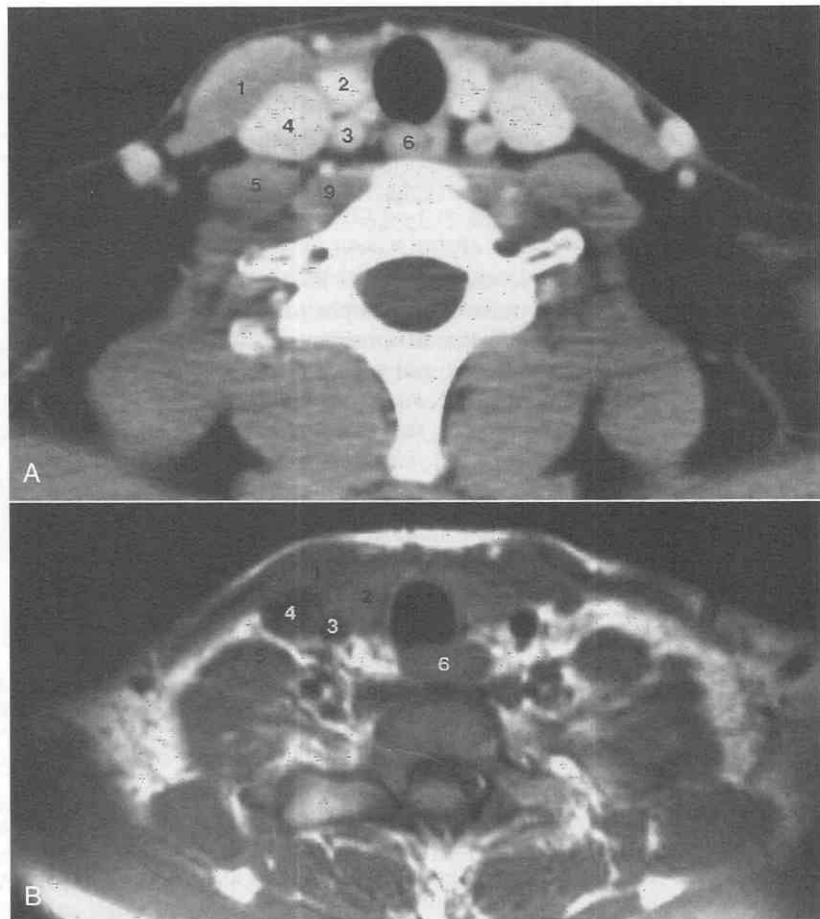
Nodal chains of the neck. (From Reede DL, Bergeron RT: CT of cervical lymph nodes. *J Otolaryngol* 11:411, 1982.)
